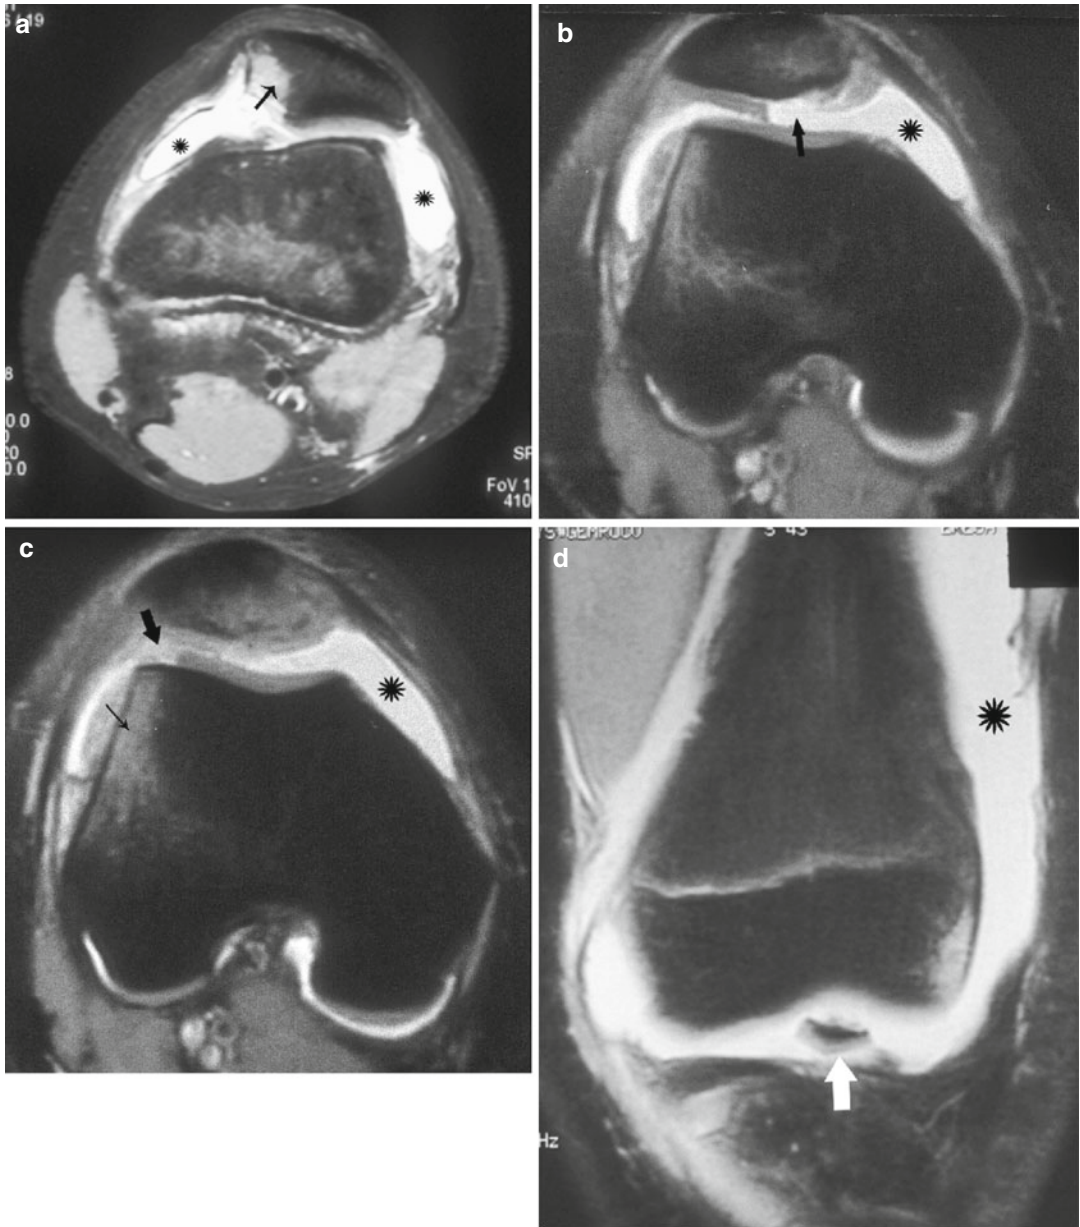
MRI signs of acute lateral patellar dislocation: contusions of the anterior portion of the lateral femoral condyle and of the medial patellae (*black thin arrow*), osteochondral defects (*black thick arrow*), intra-articular bodies (*white thick arrow*), and joint effusions (*asterisk*).
